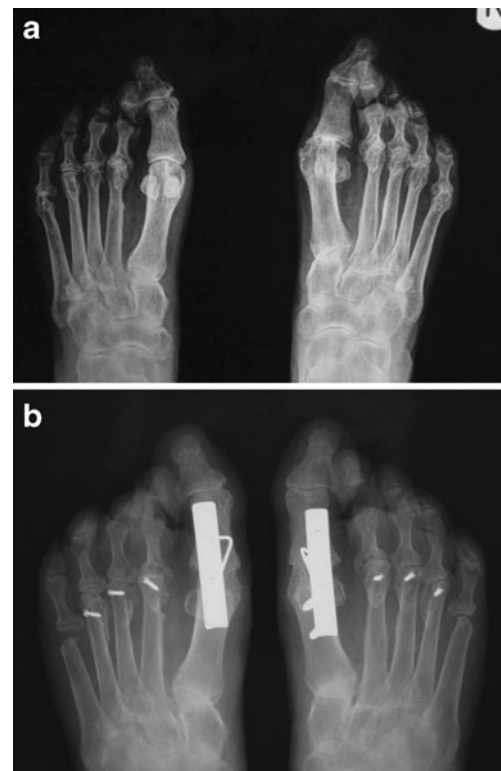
a Severe rheumatic forefoot deformity in a female patient with long-standing rheumatoid arthritis. b Post-operative radiograph after arthrodesis of the first ray and oblique shortening osteotomy of the lesser metatarsals and resection of the fifth metatarsal head in combination with trochlear resection of lesser toes
